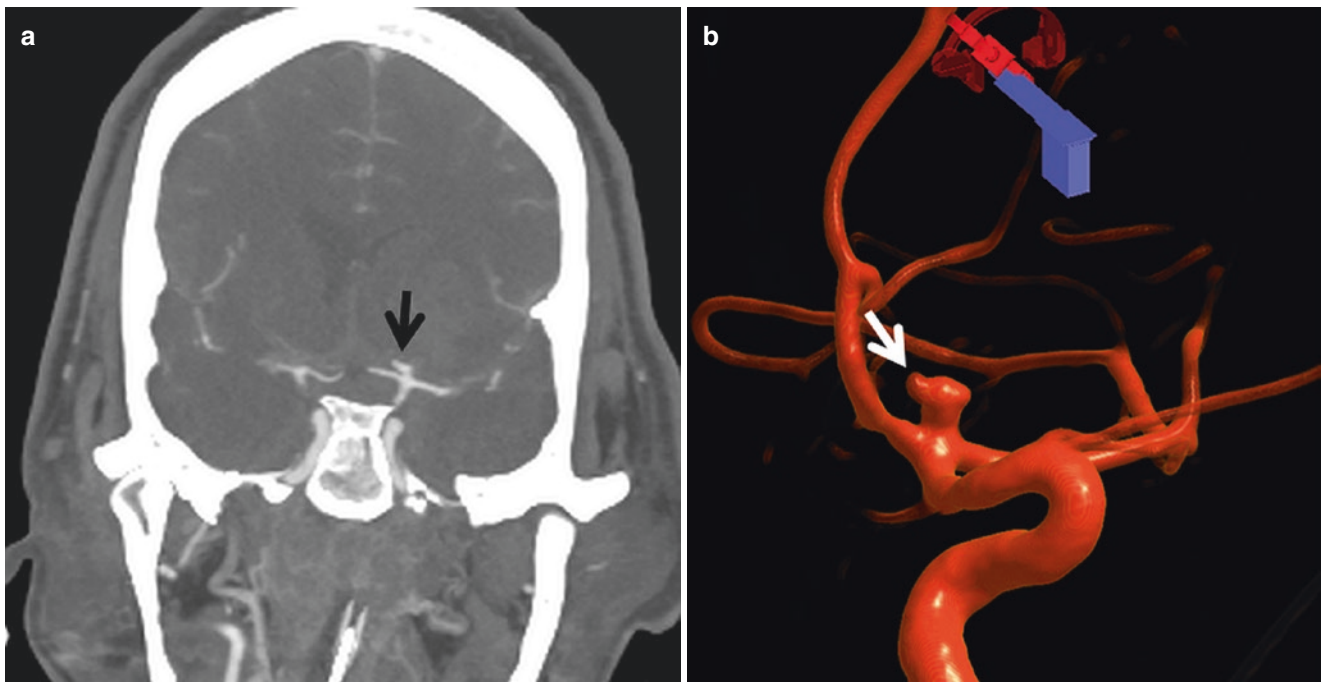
ICA terminus aneurysm. (a) Coronal CTA demonstrates a superiorly projecting aneurysm from the ICA terminus. (b) 3-D rotational angiography confirms the aneurysm. Note the small lobule at the dome of the aneurysm, which is likely the point of rupture
